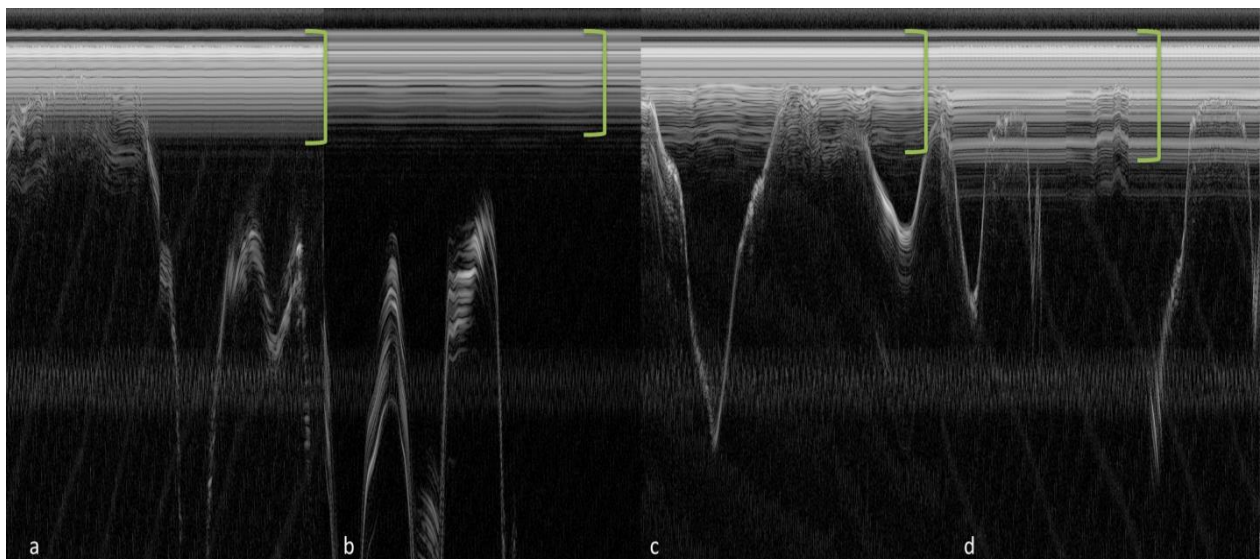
Ultrasound image with different sheaths a) without sheath b) using commercial IVUS sheath c) Pebax 55D d) Pebax 72D green brackets denote the ring down effect caused by the ultrasound pulse and sheath.
